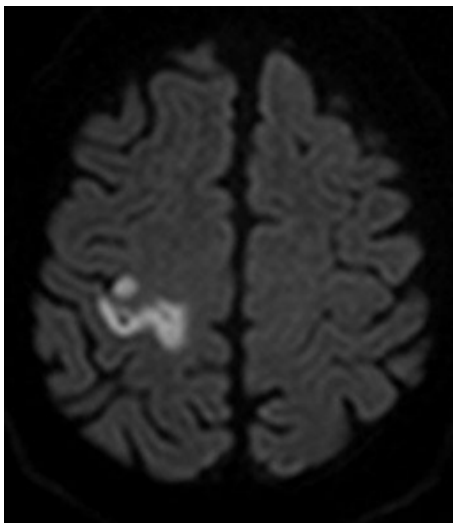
New MRI lesions in patients with TIAs and minor stroke. The risk of stroke recurrence is significantly higher in patients with abnormal MRI scans.
